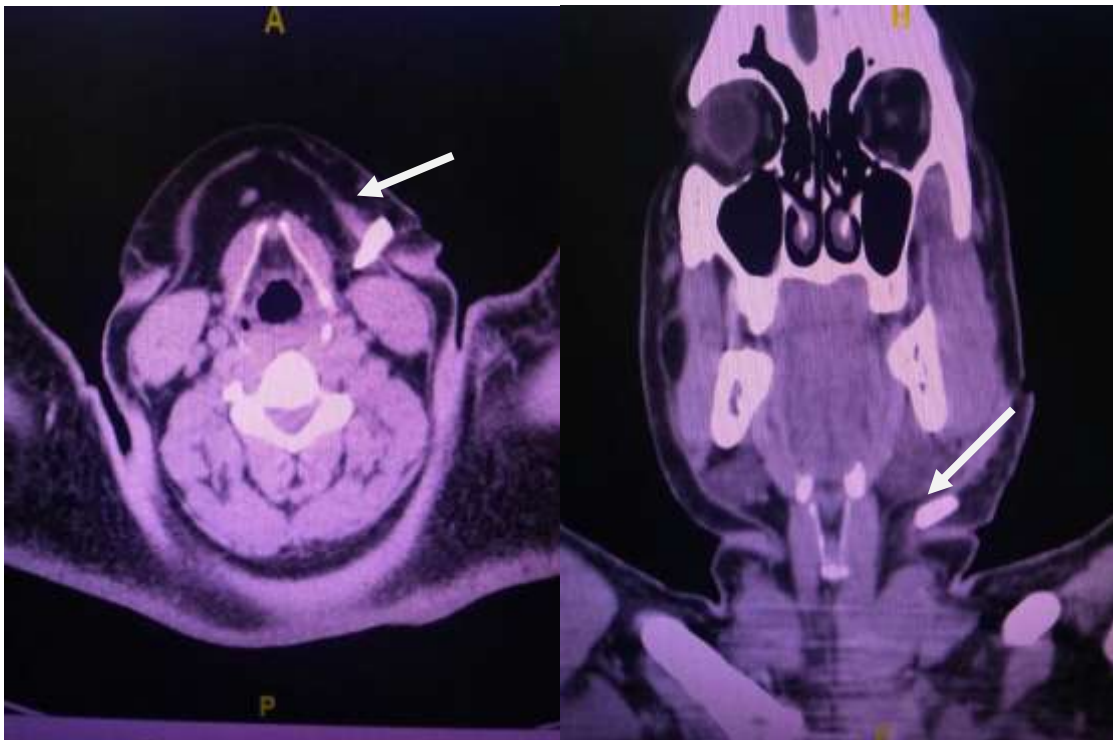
CT (axial and coronal views) showing the presence of foreign body(white arrow)
